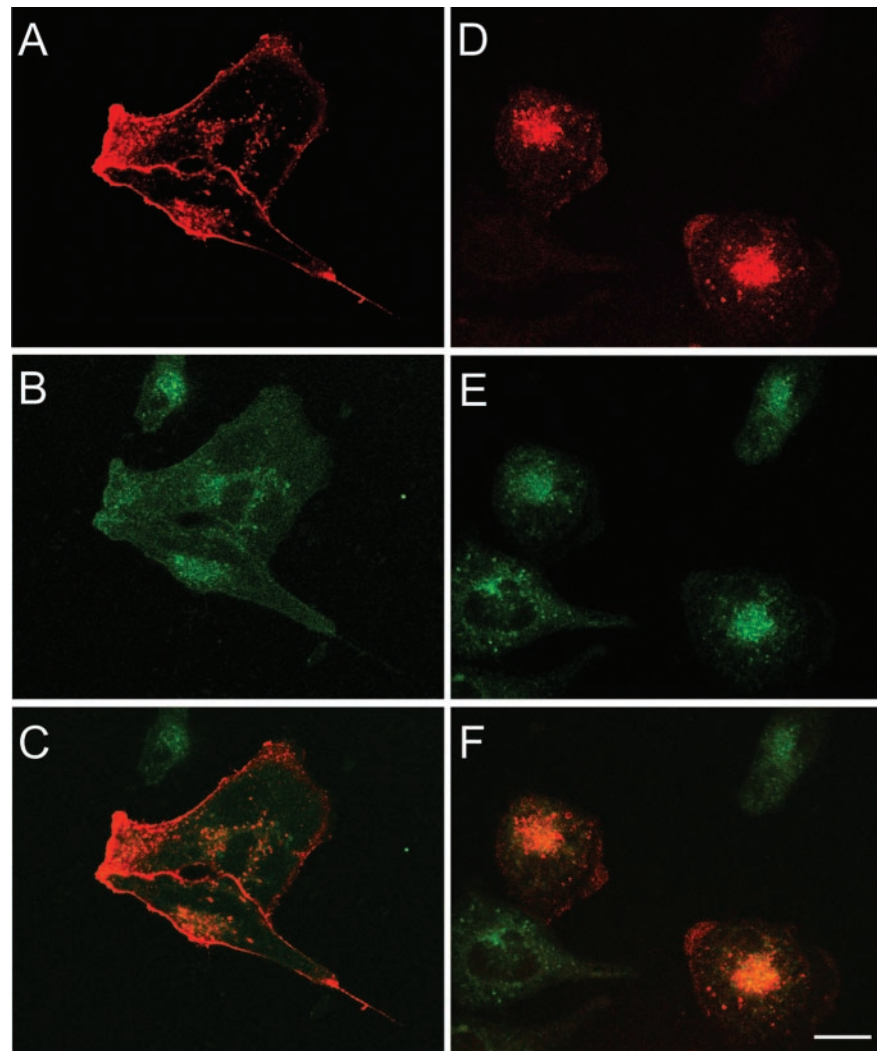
Internalization of PSMA_{wt} in HeLa cells expressing dominant-negative AP-2 complexes. PSMA_{wt} cDNA was transiently transfected into HeLa cells expressing a tetracycline-repressible dominant-negative mutant of μ 2. mAb J591 internalization was monitored in mutant μ 2-induced cells (A) and in noninduced cells (D). (B and E) Internalization of FITC-transferrin. (C and F) Merged images. Bar, 5 μ m.
